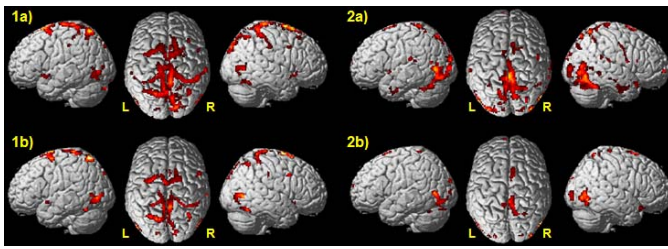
Activation pattern while playing ‘Footbag’ scenario in a 1.5T MRI-Scanner - 1a) Patient 1 before intervention, 1b) Patient 1 after intervention, 2a) Patient 2 before intervention, 2b) Patient 2 after intervention.
